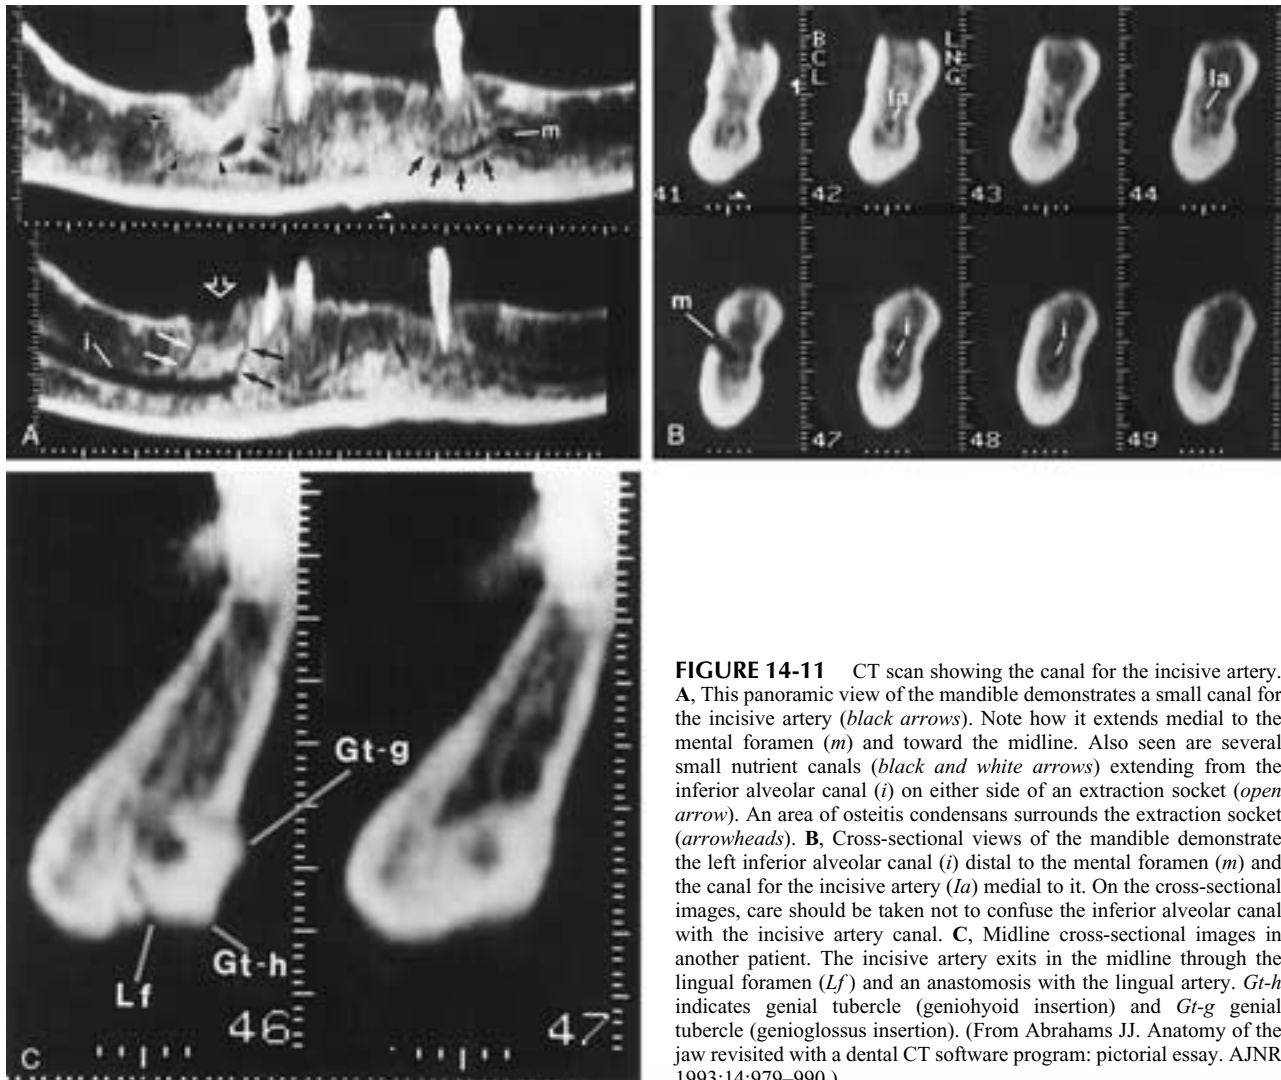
CT scan showing the canal for the incisive artery. A, This panoramic view of the mandible demonstrates a small canal for the incisive artery (black arrows). Note how it extends medial to the mental foramen (m) and toward the midline. Also seen are several small nutrient canals (black and white arrows) extending from the inferior alveolar canal (i) on either side of an extraction socket (open arrow). An area of osteitis condensans surrounds the extraction socket (arrowheads). B, Cross-sectional views of the mandible demonstrate the left inferior alveolar canal (i) distal to the mental foramen (m) and the canal for the incisive artery (Ia) medial to it. On the cross-sectional images, care should be taken not to confuse the inferior alveolar canal with the incisive artery canal. C, Midline cross-sectional images in another patient. The incisive artery exits in the midline through the lingual foramen (Lf) and an anastomosis with the lingual artery. Gt-h indicates genial tubercle (geniohyoid insertion) and Gt-g genial tubercle (genioglossus insertion). (From Abrahams JJ. Anatomy of the jaw revisited with a dental CT software program: pictorial essay. *AJNR* 1993;14:979–990.)
